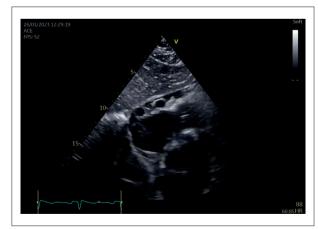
Right Coronary Artery Ectasia and Fistula to the Coronary Sinus. Panel A: Transthoracic echocardiogram (TTE) in subcostal view, showing round pericardial structures (yellow arrows). Panel B: TTE with Doppler, showing vascularization of the structures (white arrows). Panel C: Transesophageal echocardiogram showing a giant right coronary artery (RCA) (green arrow) with turbulent flow inside. Panel D: Computed tomography coronary angiography (CTCA) showing an ectatic RCA with fistulation to the coronary sinus (CS) (red arrow). Panel E: CTCA Posterior view showing the CS (blue arrow), the ectatic RCA (purple arrow), and the location of the fistula (green square). Panel F: CTCA Anterior view showing the RCA (purple arrow), the anterior descending artery (Blue arrowhead), a marginal artery (white arrowhead), and the circumflex artery (red arrowhead).
